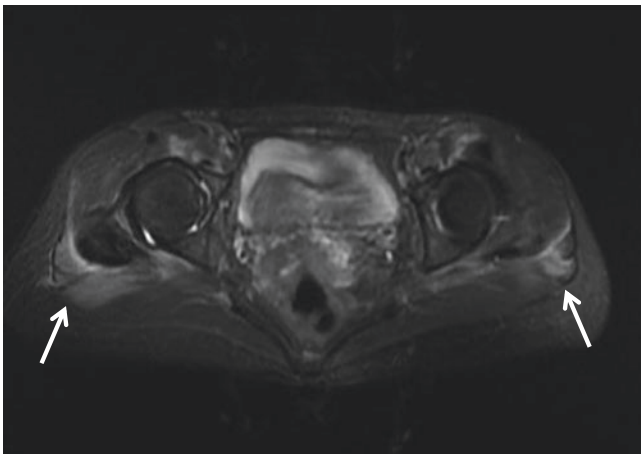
Clinical diagnosis was DM. MRI scan demonstrated enhancement of bilateral gluteus maximus muscles consistent with FDG accumulation (arrow)
